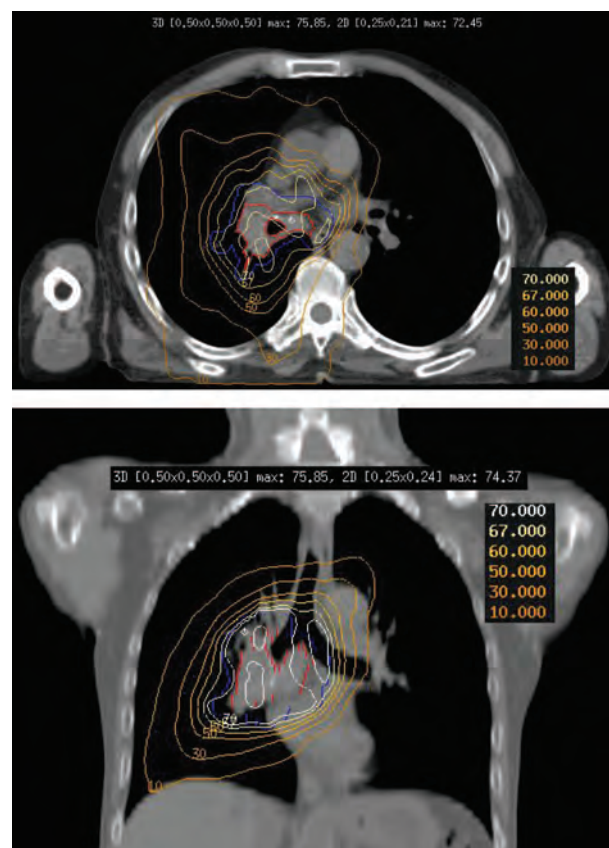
Isodose distribution on transverse (top panel) and coronal (bottom panel) sections. The GTV-T + N (FDG-PET + CT, 0 Gy) is delineated in red; the PTV-T + N (FDG-PET + CT, 0 Gy) is delineated in blue.
